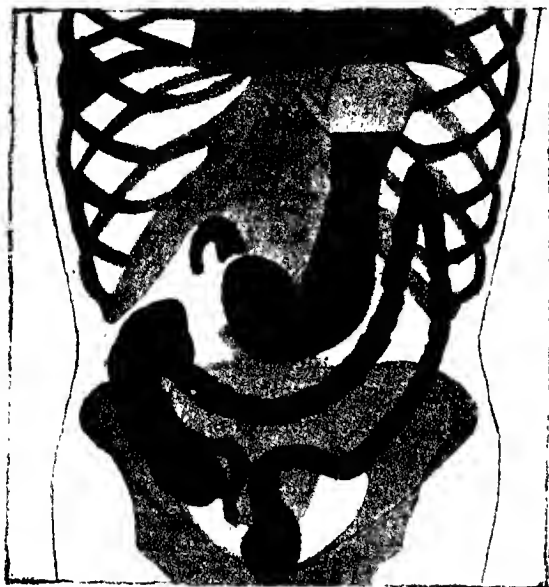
Radiograph of a normal stomach in the vertical position. (From A. F. Hertz).
